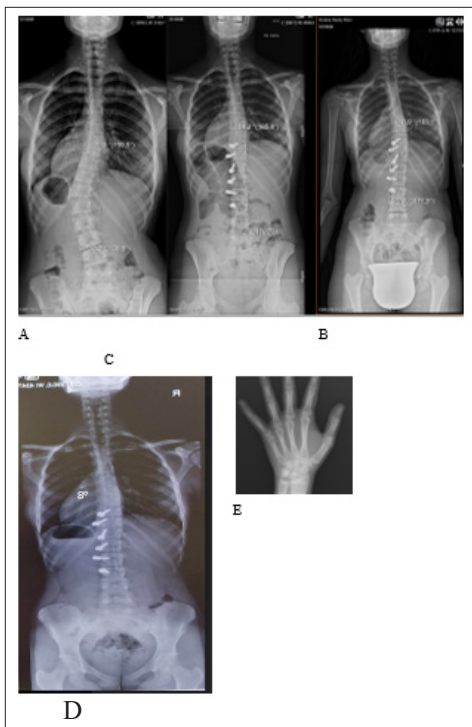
Despite being 13yo and a Sanders 6 / Risser 3, she developed proximal overcorrection at 1y post-op (shoulders unbalanced) AP spinal radiographs: A. pre-op, B post-op, C. 1y FU, D. post-tether release (shoulders balanced), E. Hand X-ray Sanders 6
